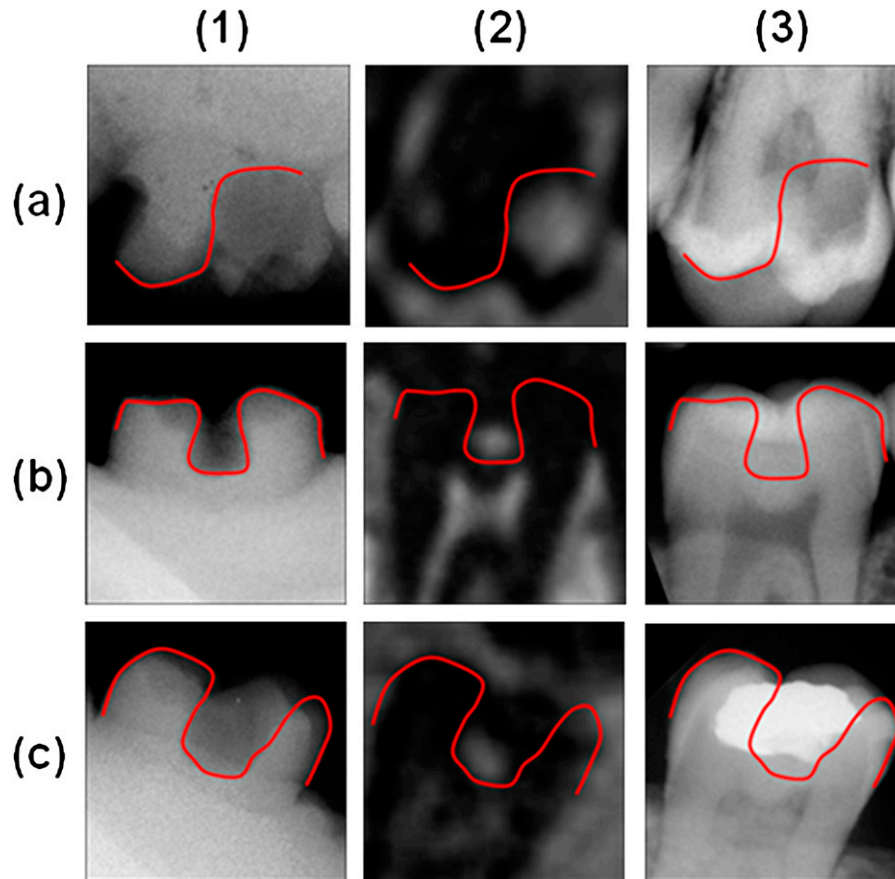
In situ* measurements: comparison between (1) X-ray of the impression, the appearance of the respective lesion in (2) ultrashort echo time and (3) intraoral X-ray of (a) a smooth surface caries, (b) a hidden caries and (c) a secondary caries lesion
